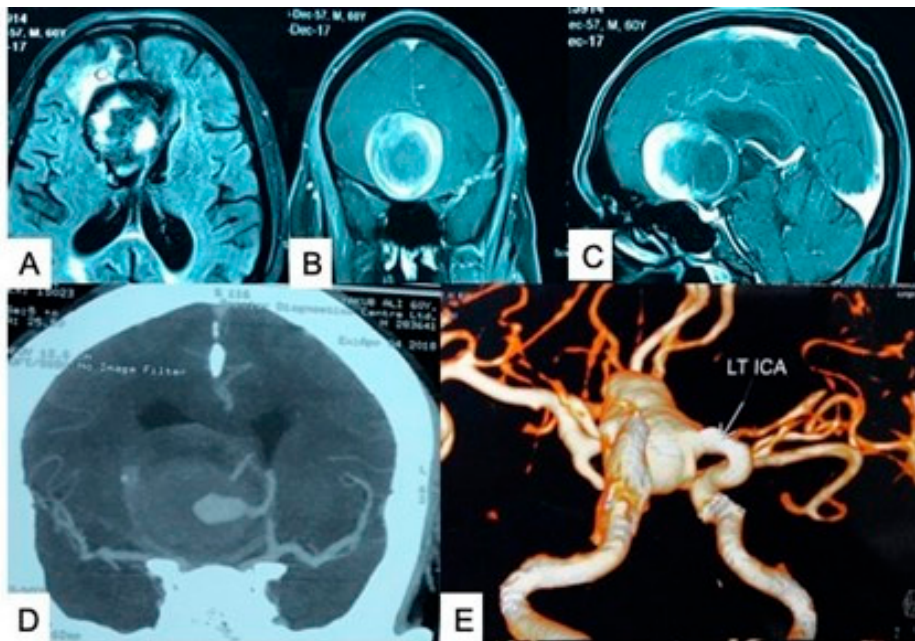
(A–C) MRI axial, coronal and sagittal view showing a thrombosed ACOM aneurysm. (D) CT angiogram in coronal view showing a partially thrombosed ACOM aneurysm. (E) CT angiogram showing a giant ACOM aneurysm. Source: Figure by authors.
